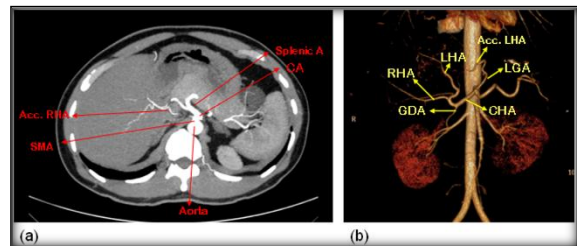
MIP CT angiograms of abdominal aorta showing axial view of Type VI with accessory RHA from the SMA (a) and 3D reconstructed image of Type V showing accessory LHA from the LGA (b)
